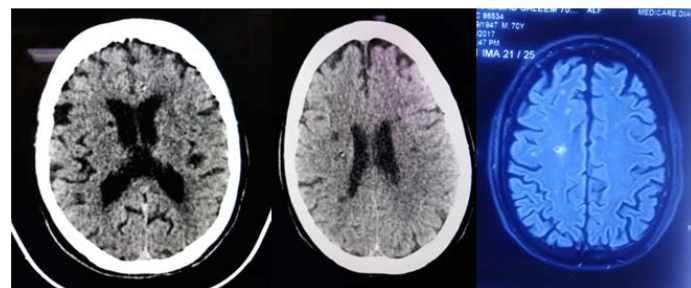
CT and MRI showing lacunar infarcts
